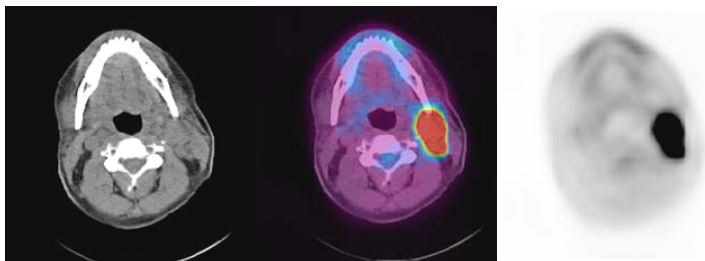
The patient was a 45 year old man who underwent a kidney and pancreatic transplant twelve years prior to presentation with neck discomfort and swelling. A tonsillectomy resulted in diagnosis of polymorphic PLTD. His initial PET/CT demonstrated two soft tissue masses in the left neck.
